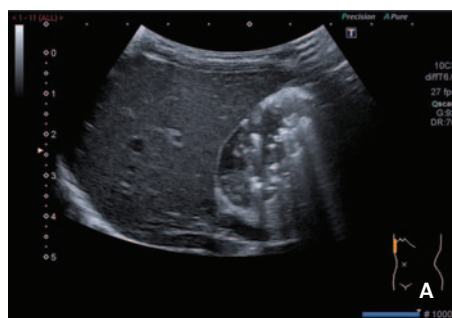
An eight-day-old baby with persistent non-bilious vomiting since birth and dehydrated with metabolic alkalosis. (A) Ultrasound of the abdomen, performed to rule out pyloric stenosis, showing a normal pylorus. The distended fluid-filled viscus in the region of the pylorus/duodenum raised the suspicion of duodenal obstruction. (B) The upper GI contrast study: on initial screening there was a double bubble sign with dilatation of the first part of the duodenum and a tiny amount of gas in the distal bowel. On injecting contrast, the stomach and dilated first and second portions of the duodenum are outlined with no drainage distally (C).
